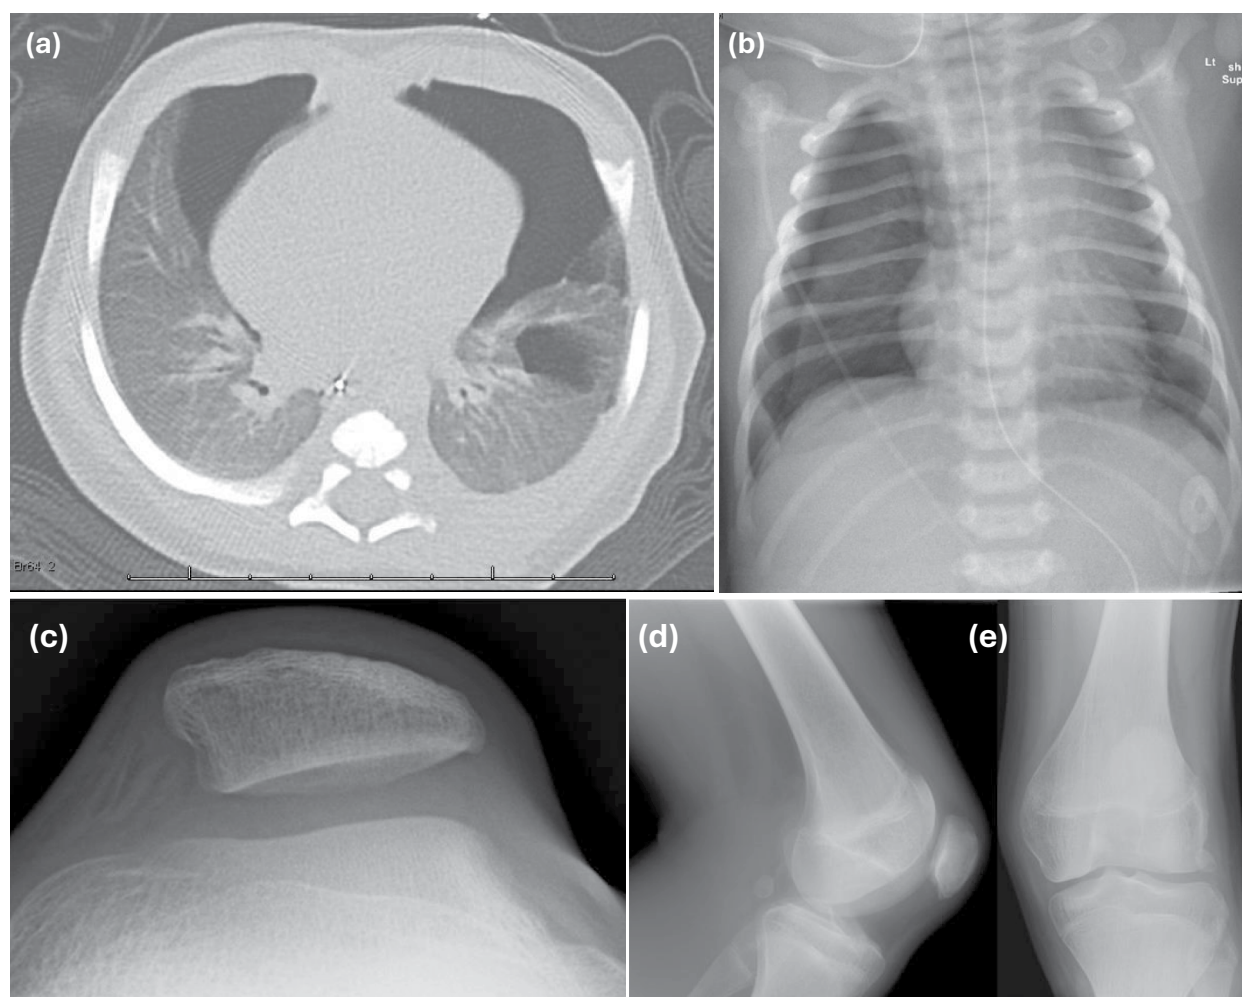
A Computed tomography (CT) chest of patient AD150-III.2 performed at day 2 of life showing moderate right and large left-sided pneumothorax, with left-sided tension, as evidenced by shift of the mediastinal silhouette rightward, diffuse mild ground glass appearance of lungs and mild narrowing of the left pulmonary artery in the setting of a small patent ductus arteriosus and B Chest X ray taken at day two of life showing slightly underinflated lungs with right upper lobe atelectasis. C Radiographs of knee of individual 150.II.1 on skyline view showing hypoplastic patella with reduced overall ossification and lateral patellar subluxation, D Lateral view showing patellar hypoplasia and E Antero-posterior view showing hypoplastic patella and underdeveloped or flattened femoral condyle
